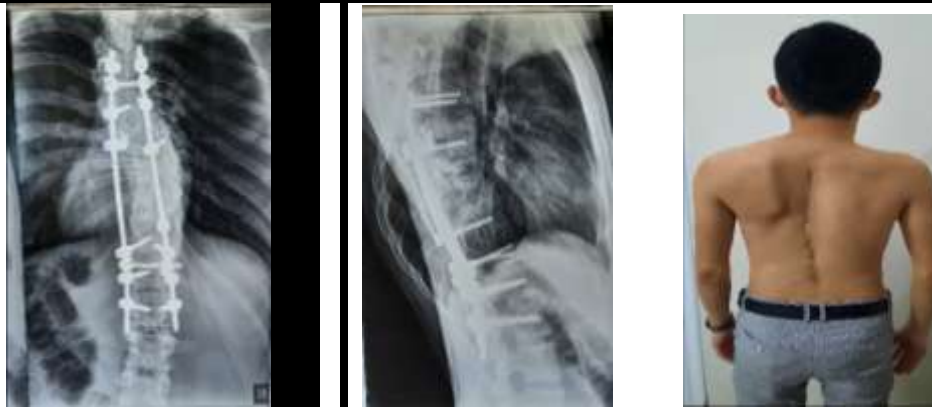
Photo and radiograph of patient A., after 6 months.
